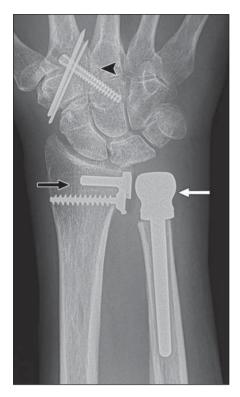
Anteroposterior radiograph of 75-year-old man shows nonconstrained distal radioulnar joint replacement with ulnar head replacement (*white arrow*) in distal ulna and Sigmoid Notch (Small Bone Innovations) implant (*black arrow*) in distal ulna. Screw (Acutrak, Acumed) (*arrowhead*) and Kirschner wires across second carpometacarpal joint are also noted.
